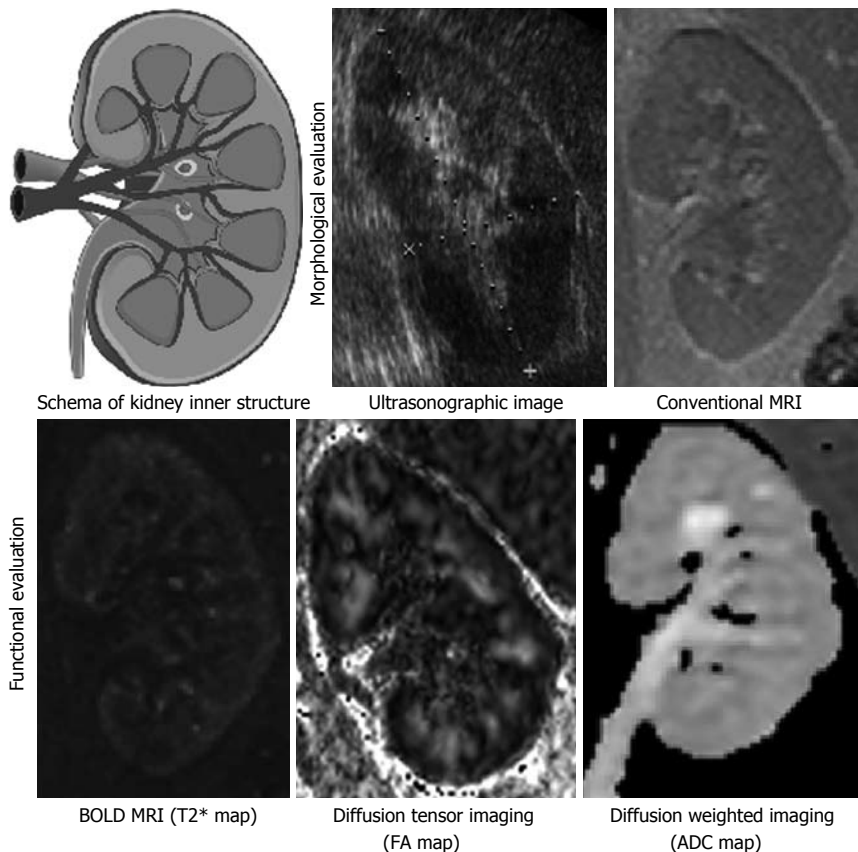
Various modalities for kidney. It is noteworthy that the cortex and medulla are distinguishable on the basis of function or microstructure in functional MRI. For example, in T2* map of BOLD MRI, the medulla was seen darker than the cortex because of the difference in amount of deoxy-hemoglobin; in FA map of diffusion tensor imaging, FA of medulla was higher than the cortex probably because straight microstructure of medulla including distal tubules and surrounding blood capillaries restrict irregularity of Brownian movement of protons. Contrast and angle are adjusted respectively. Each of the kidney images is of a different patient. BOLD: Blood oxygenation level-dependent; MRI: Magnetic resonance imaging; FA: Fractional anisotropy; ADC: Apparent diffusion coefficient.
